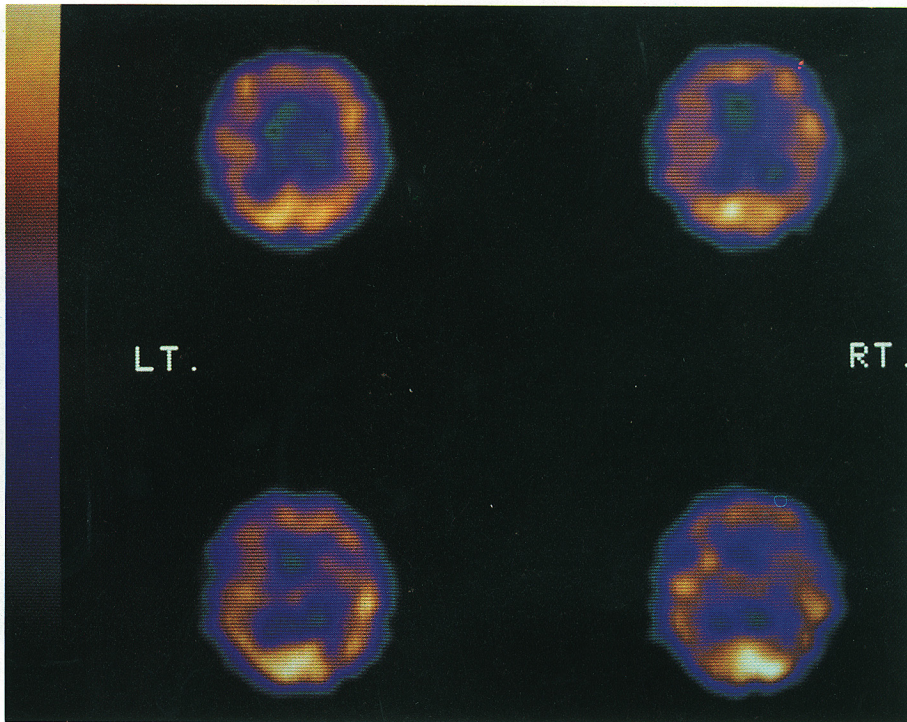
SPECT with  $^{99m}\text{Tc}$ -HM-PAO 8 days after delayed neurologic sequelae after CO poisoning showed patched decreased perfusion throughout the cerebral cortex (patient 3).
